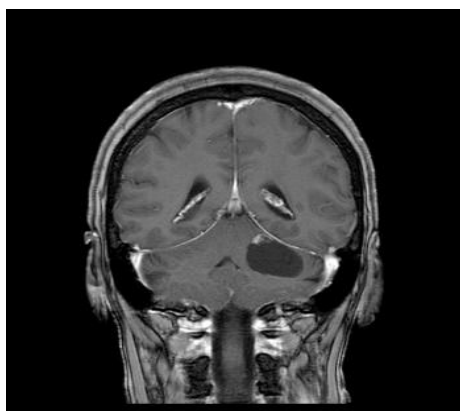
Initial Contrasted MRI
